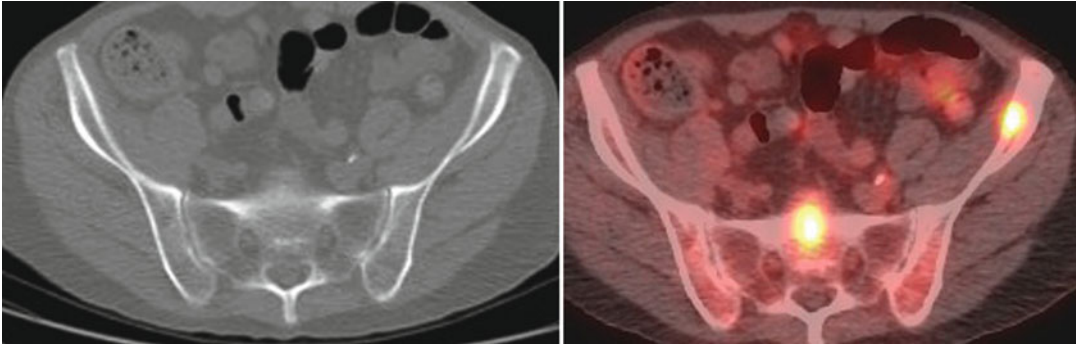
Bone marrow metastases. Axial CT and fused PET/CT image show foci of FDG uptake in sacrum and left ilium with evidence of bone erosion or destruction.
